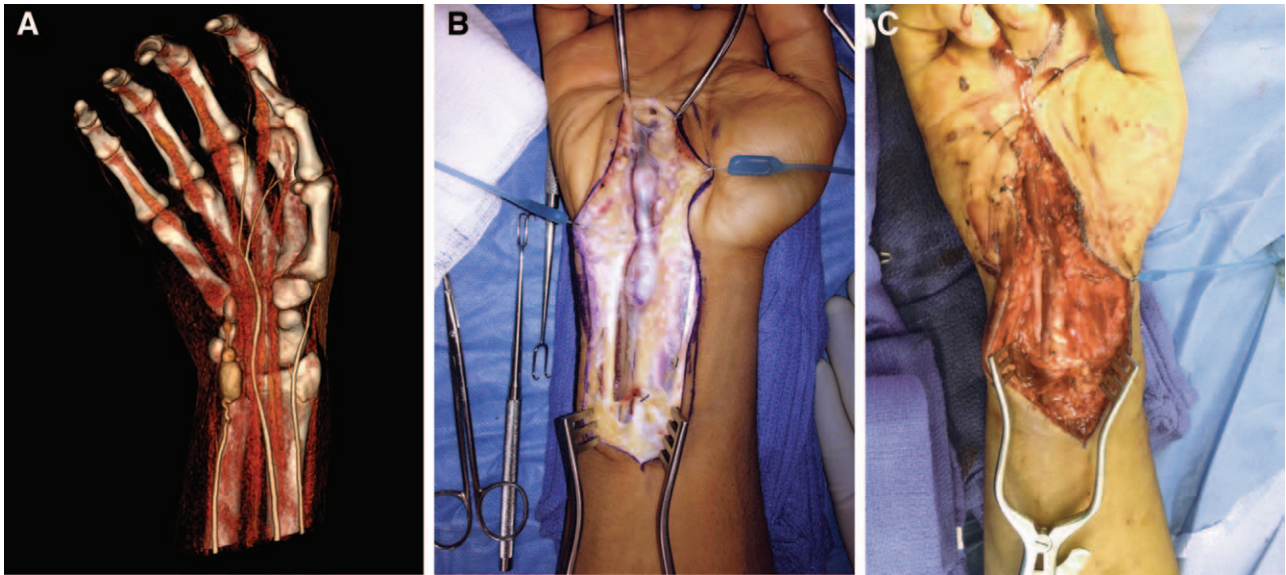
Computed tomography angiogram (A) demonstrating the presence of a multilocular ulnar artery aneurysm, a persistent median artery, and absence of the palmar arterial arch system. Under tourniquet, the aneurysm was approached with a direct incision, exposing the entirety of the lesion from the mid-forearm proximally to the mid-palm distally (B). After resection of the lesion, the ulnar artery was reconstructed with a reversed cephalic vein graft harvested from the ipsilateral forearm (C).
